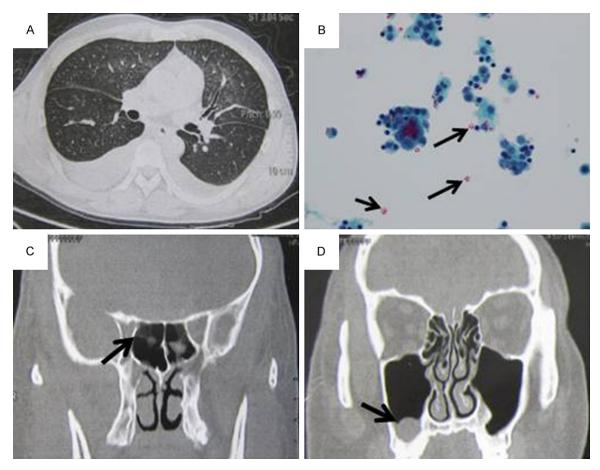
A. Chest computed tomography (CT) scan revealing ground glass opacity in the bilateral upper lobes of the lungs and middle lobe of the right lung as well as pleural effusion. B. Cytological examination of pleural effusion showing eosinophilia (black arrow). C. CT scan of the head showing a thickened nasal mucosa (black arrow). D. An isodense and homogeneous tissue occupying a portion of the right maxillary sinuses (black arrow).
